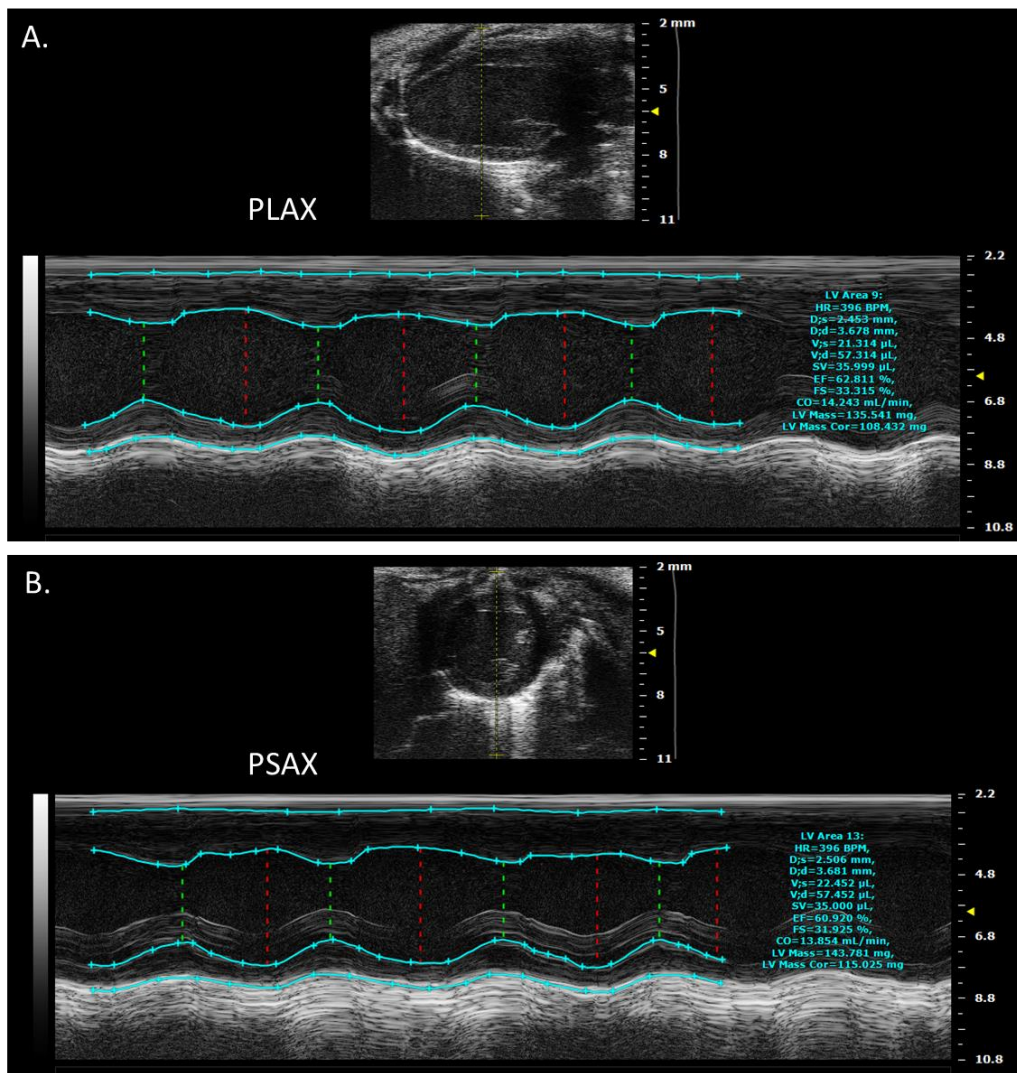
Echocardiography analysis of M-mode images. Images to show analysis of (A) parasternal long axis (PLAX) and (B) parasternal short axis (PSAX).
